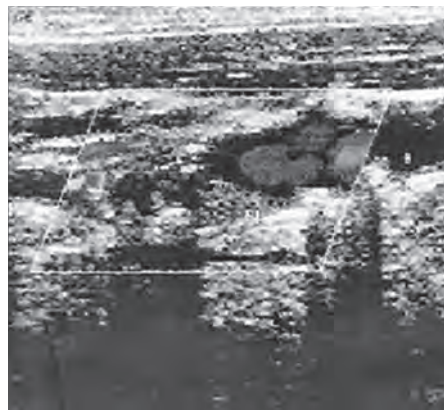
Colour Doppler—grossly reduced colour flow in the left ICA
